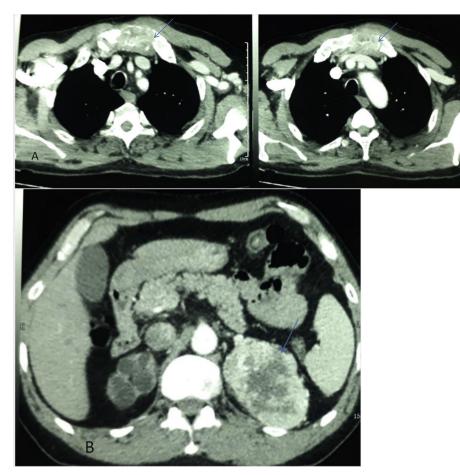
A: Contrast enhanced CT scan in the axial plane showing a lesion of $6 \times 4 \times 2$ cm in the manubrium invading adjacent soft tissue. B. Contrast enhanced CT scan in the axial plane showing heterogeneous and avidly enhancing mass in the left kidney, with hypodense central areas indicative of necrosis.
